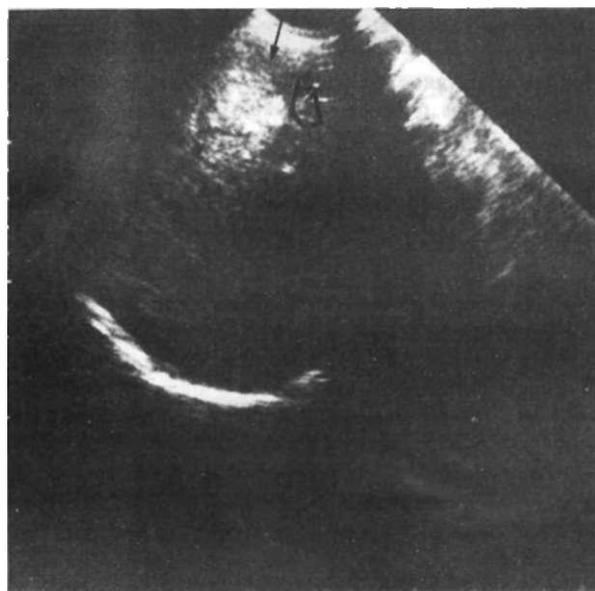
Ultrasonogram, belonging the same patient (Fig. 1) shows an hyperechoic mass lesion (arrow) being hypoechoic before treatment two years ago.
